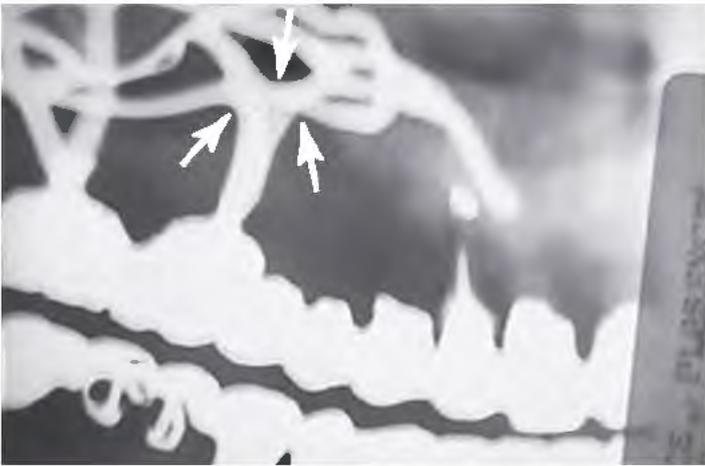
Witness marks are grooves cut across the crest of the ridge to allow flush seating of the primary struts of subperiosteal implants. However, these marks should never be used, because geometric patterns cut into bone do not retain their sharp line angles. This radiograph shows the pathologic downfall of an implant under which such grooves had been cut and subsequently were resorbed into rounded troughs (*arrows*).
